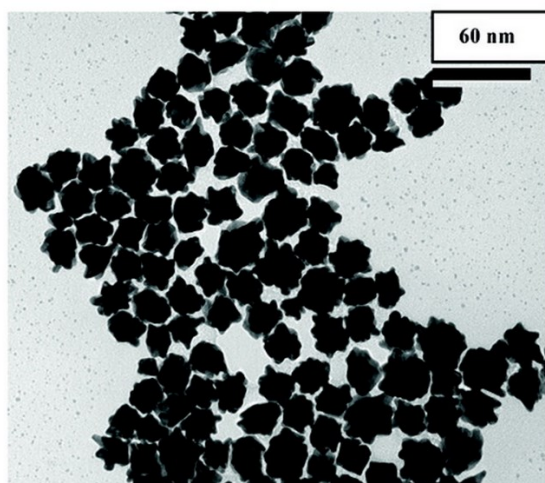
A TEM image of anti-PSMA antibody conjugated gold nanopopcorn (adapted from Reference 63)
